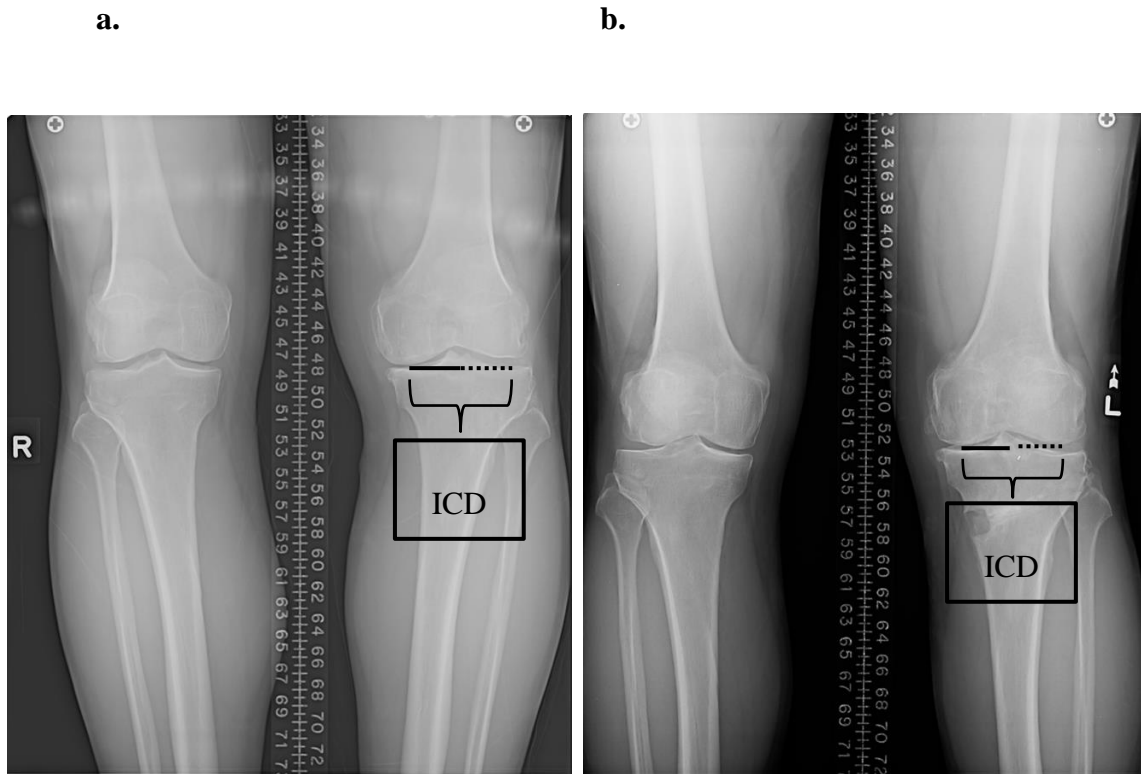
Example of patient radiograph. A. before and b. 12 months after MOWHTO where the affected study limb is the left knee. The distance of the medial contact point to the knee joint center was obtained by measuring the distance between the medial femoral contact point and the knee joint center (solid line). The distance of the lateral contact point to the knee joint center was obtained by measuring the distance between the lateral femoral contact point and the knee joint center (dotted line). The total intercondylar
